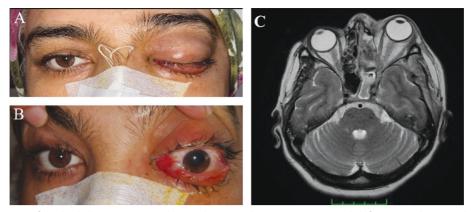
Clinical findings A female diabetic patient in her early 30s with mucormycosis with left eye involvement had periorbital edema, proptosis, chemosis, ptosis, and frozen eye (A and B). MRI shows left eye proptosis with involvement of the left orbital apex secondary to ethmoid sinusitis (C). MRI: Magnetic resonance imaging.
